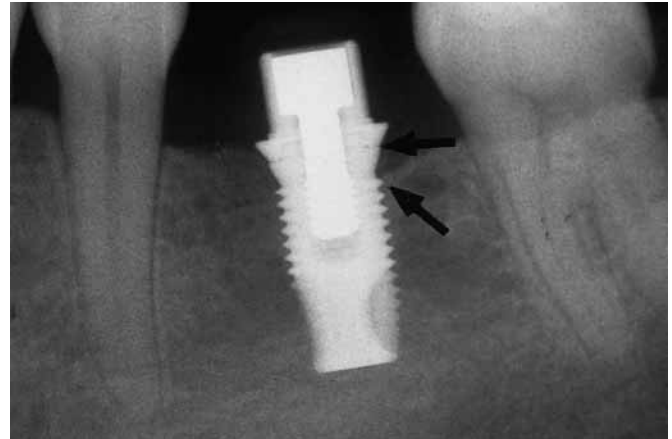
Radiograph of a Wide Platform fixture (Nobel Biocare®). Implant diameter of 5 mm and smooth collar of 5.1 mm.
